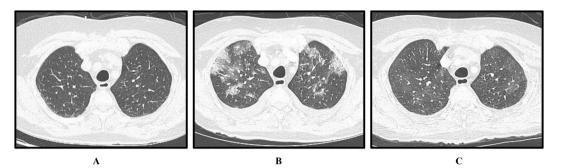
Axial views of patient's chest CT scan at different points during her hospital admission. A: Six days prior to receiving bortezomib; B: Two days after receiving bortezomib; C: Nine days after receiving bortezomib.
